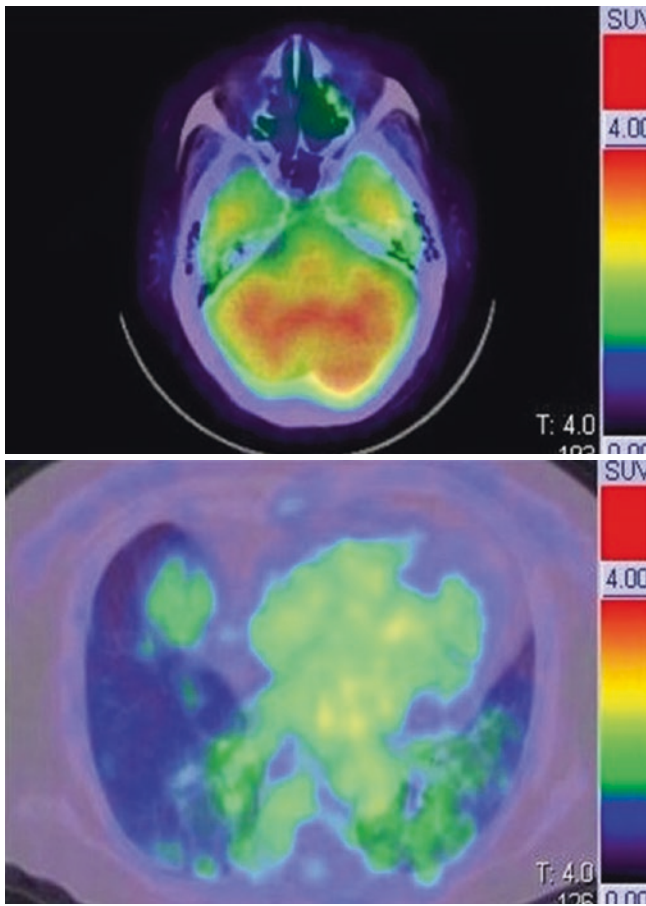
The patient was diagnosed with GPA using nasal biopsy from ^{18}F -FDG uptake area. A follow-up ^{18}F -FDG PET/CT in this figure showed no ^{18}F -FDG uptake in the nasal mucosa after the administration of prednisolone and immunosuppressant therapy
